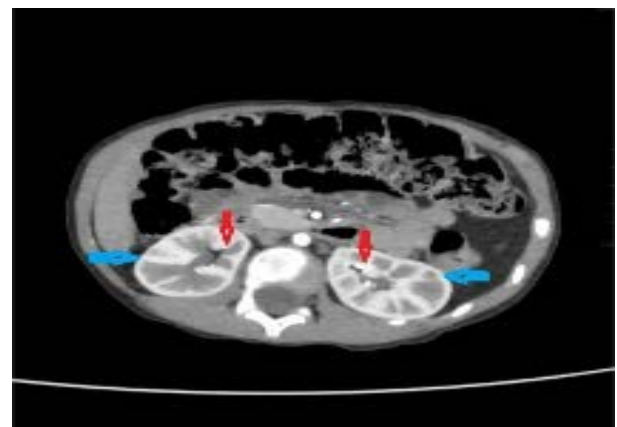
An axial CT scan of the abdomen and pelvis shows that both kidneys are normal, and there is no sign of hydronephrosis (blue arrows). Red arrows indicate the expected locations of post-surgical clips (red arrows)
